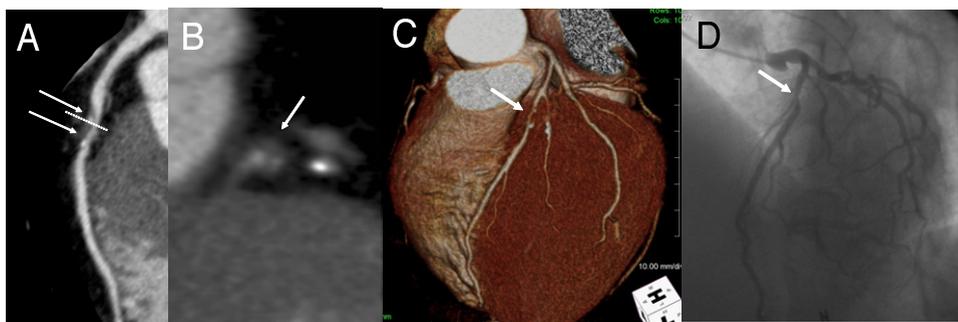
Multidetector Row Computed Tomography and Coronary Angiography in a 49-Year-Old Male Subject
